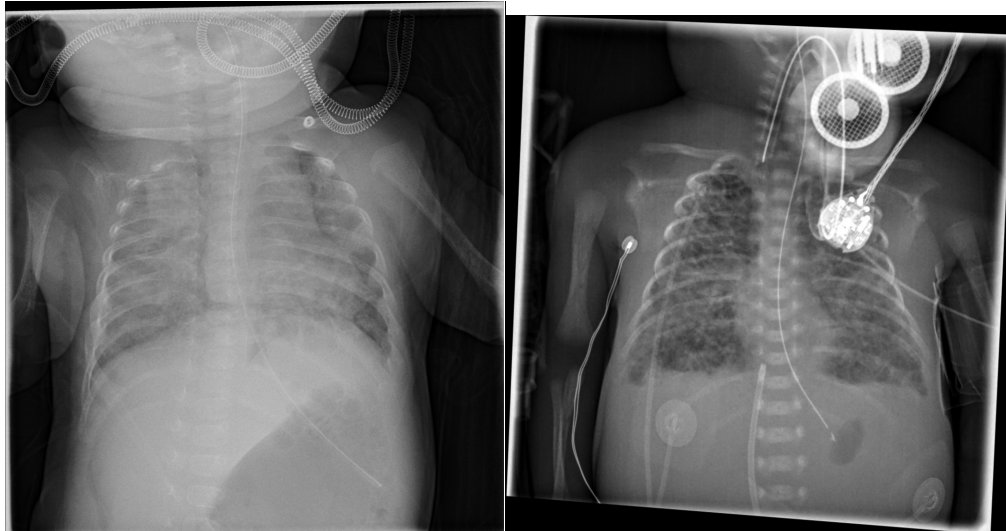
X-ray showing: A) left panel, over-distention of stomach and diffuse, non-homogeneous lung infiltrates with reduced lung volume; B) endo-tracheal tube, lung bilateral small diffuse infiltrates and interstitial emphysema, narrowed mediastinum-heart shape, flattened diaphragms, empty stomach with tube, and catheter in the inferior vena cava.
